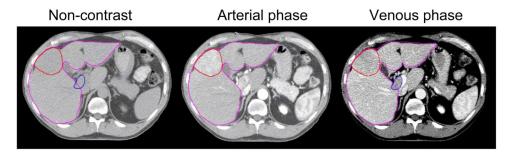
CT planning images for an HCC patient. The liver (pink), the GTV (red) and the portal vein thrombosis (blue) are shown on a noncontrast CT (left), and on arterial phase (middle) and venous phase (right) images.
